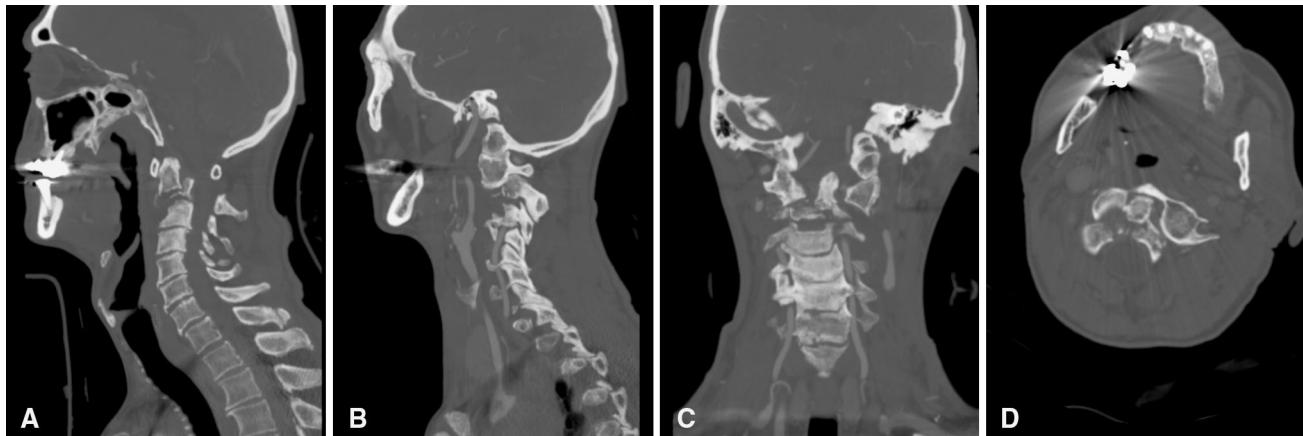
CT scan showing sagittal (a, b), coronal (c) and axial (d) dislocation of the C1C2 complex
